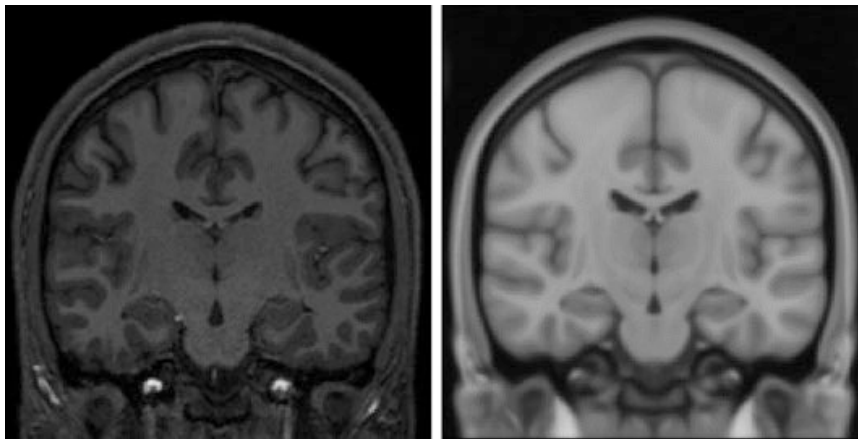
Data displayed after calling the check option. Left: T1-weighted scan co-registered to the MNI template. Right: MNI template shown after de-selecting the T1-weighted scan in freeview. Note that the scans seem to be well registered
